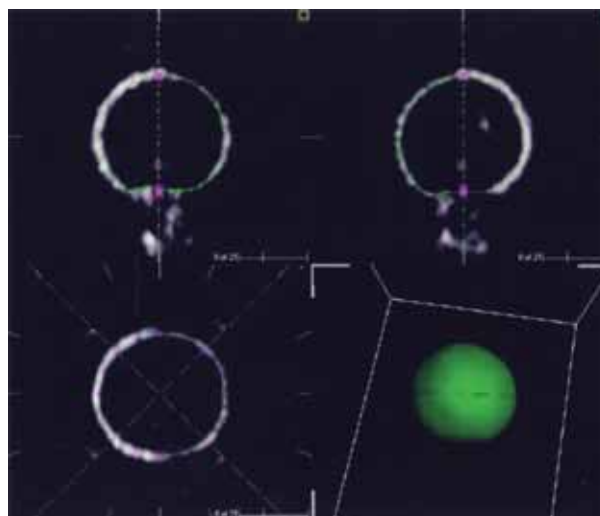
Ultrasound images of the ventricular model were calculated using 4D Cardio View RT 1.2 software. The two upper images are long-axis images, and left lower image is a short-axis image. The right lower image is a reconstructed image. Volumes of the ventricular model were calculated by manual tracing around its interior surface on two long-axis images.
